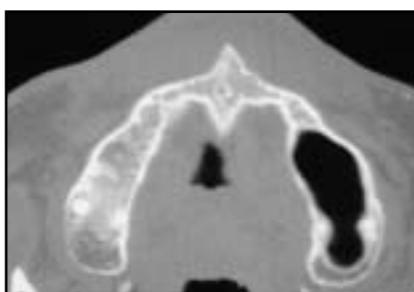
CT scan, preoperative view.
